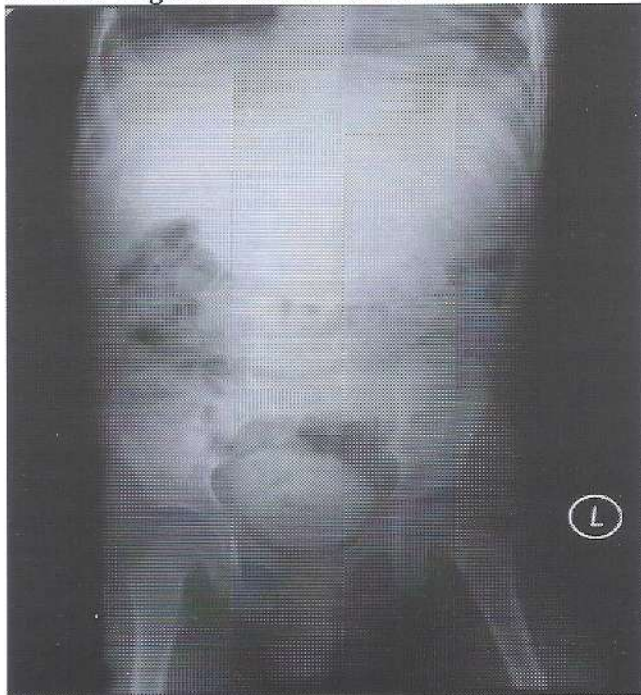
Kidney, ureter, and bladder radiograph of a 3-year-old boy showing a large bladder stone, with the largest dimension of 4.1 cm.
